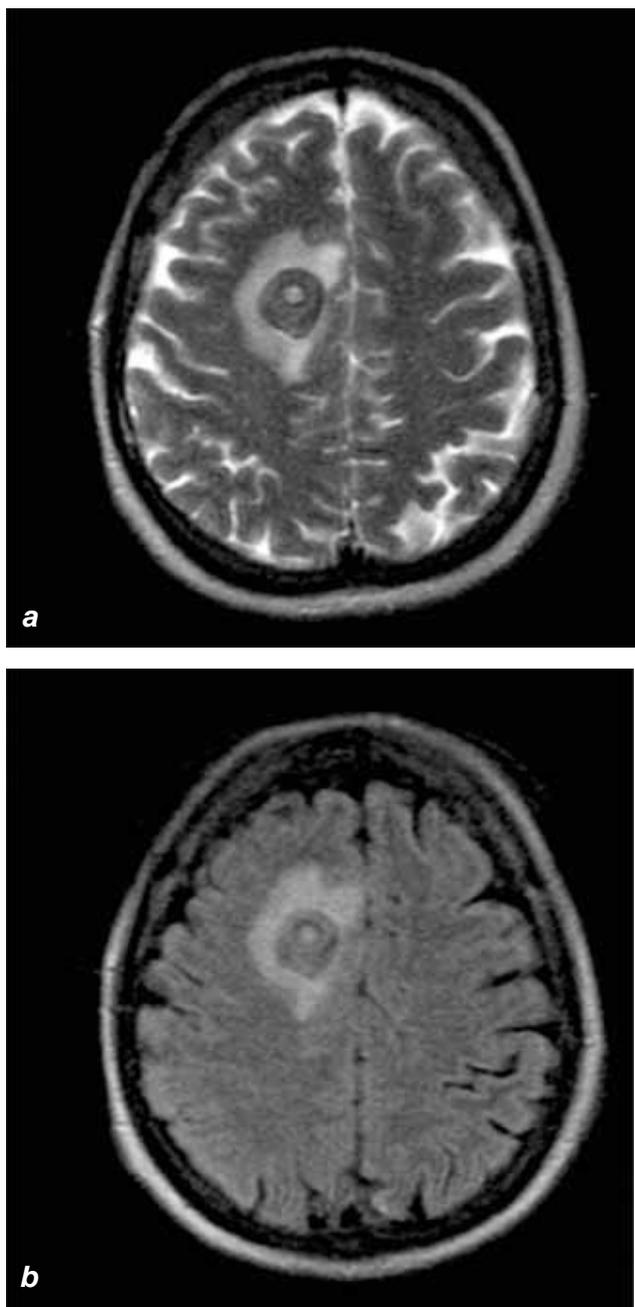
a, b Axial FLAIR and T2-weighted images show the lesion as being hypointense, inhomogenous, with a hyperintense center with the appearance of a “bull’s eye”.
